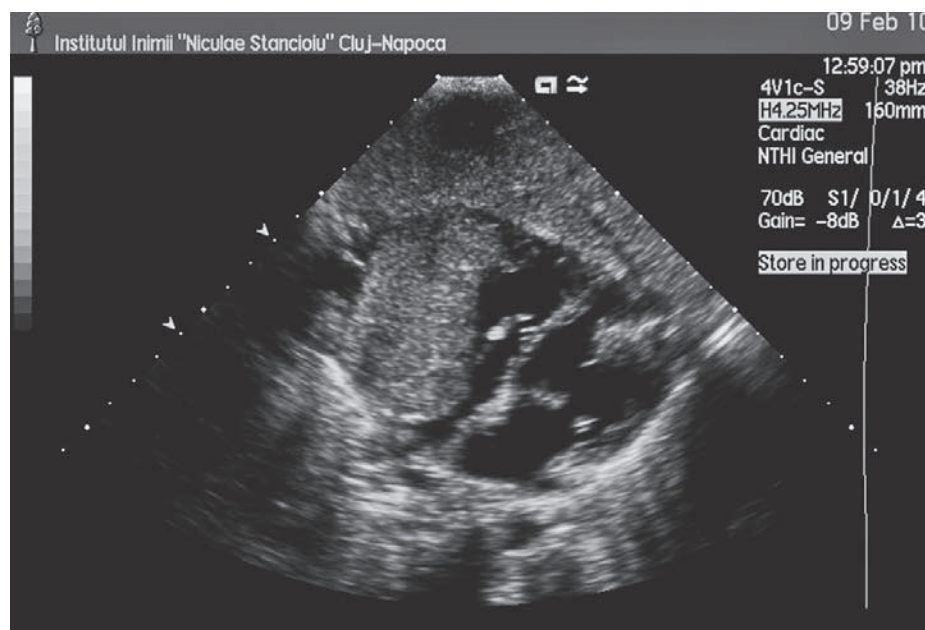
Echocardiography: giant, non-homogeneous tumor located in the anterior and lateral wall of the right ventricle and right atrium
